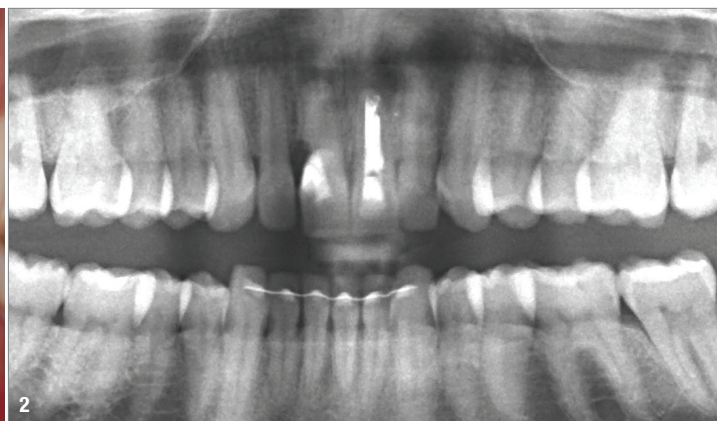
General intra-oral situation at baseline in 2016. Fig. 2: The panoramic radiograph.
